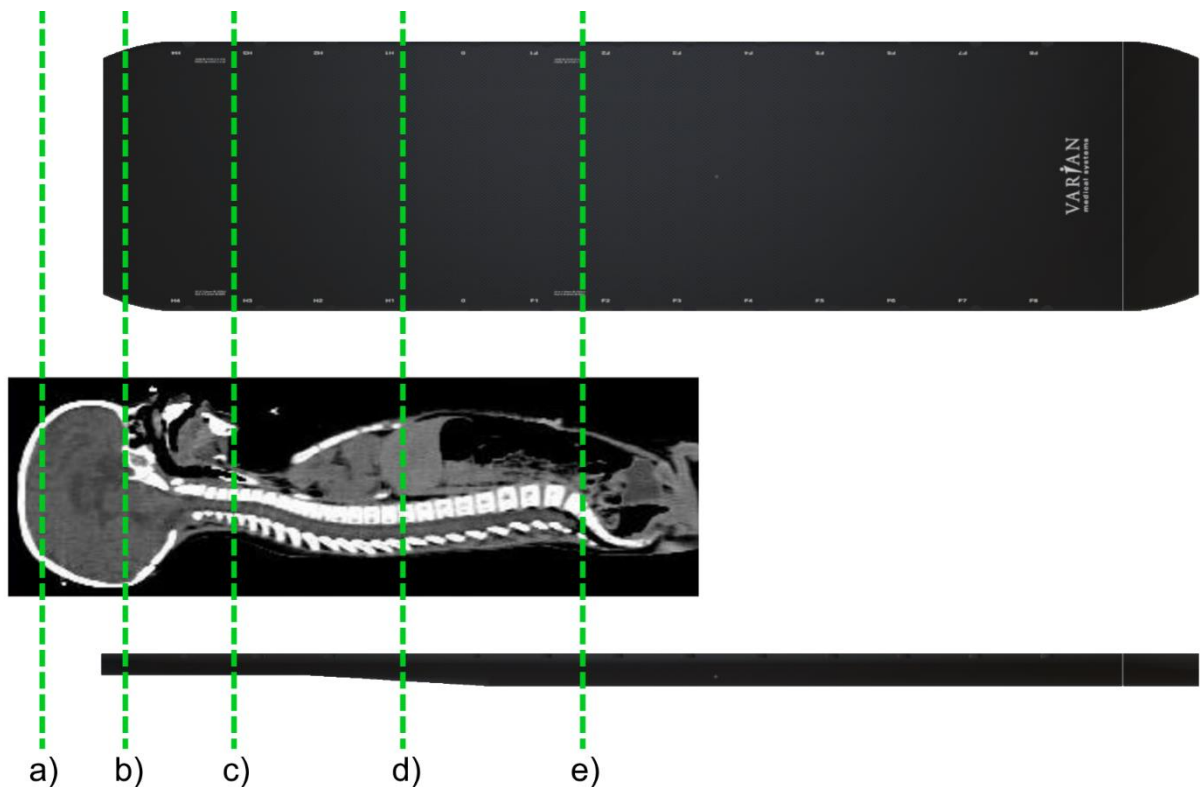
Showing how the CT Scan images are compared with the position of the couch to see which CT slices fall outside the couch
